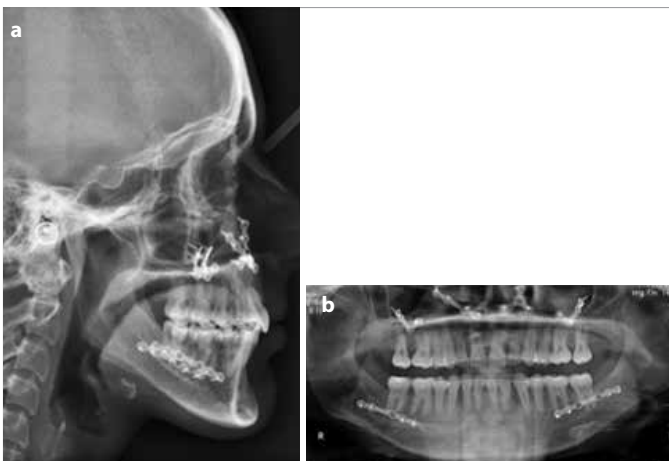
a, b. Post-treatment lateral cephalometric (a); panoramic radiographs (b)
